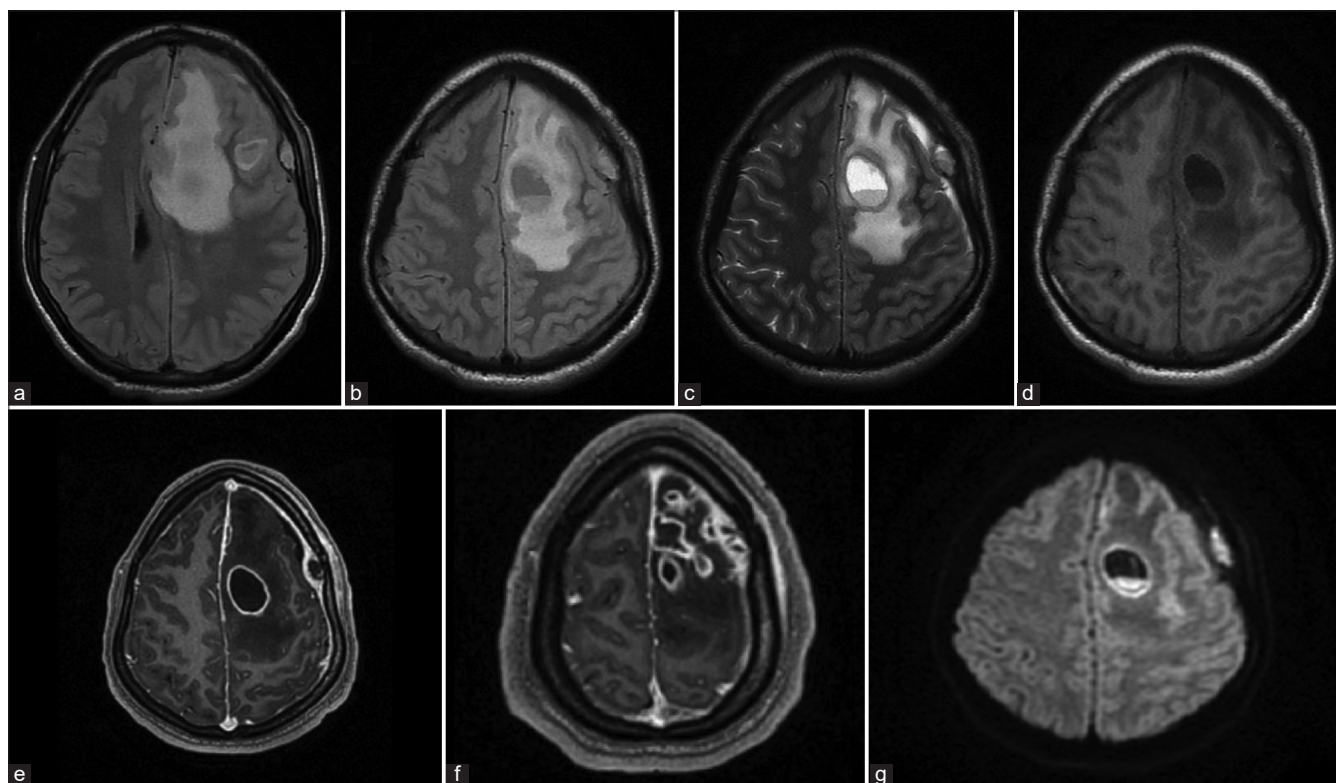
MRI findings (a) MRI T1 showing intraparenchymal abscess and edema causing mass effect, (b) MRI T1 fluid-fluid level in the abscess, (c) MRI T2 shows hyperintense collection in subdural and epidural space, (d) MR Flair shows hyperintense extra-axial collection, (e and f) MR Contrast showing multiple ring-enhancing lesions, sub dural, and epi dural collections, (g) Diffusion restriction noted along the capsule and contents of the abscess.
